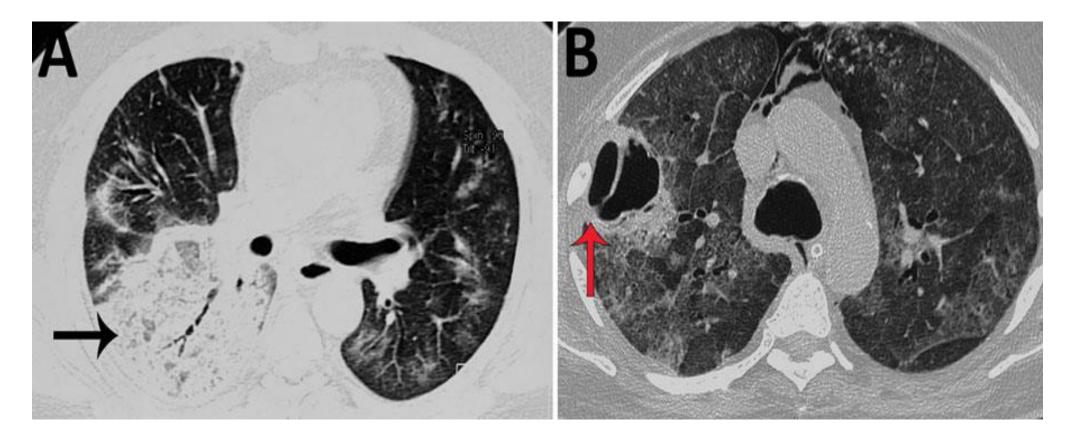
Noncontrast computed tomography scan of the thorax of a patient with coronavirus disease– associated mucormycosis, India, 2020. A) Pulmonary mucormycosis demonstrated as a large area of consolidations with patchy air trapping (black arrow), patchy ground-glass opacities, and septal thickening; B) large thick-walled cavity (red arrow) with surrounding ground-glass opacities.
